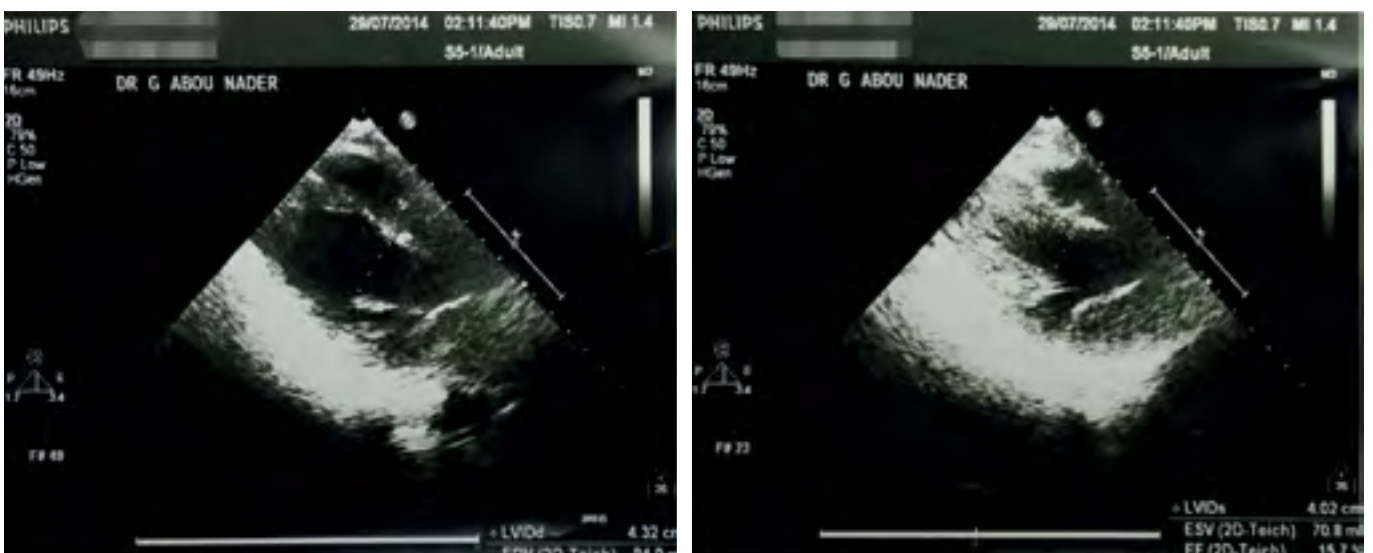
Left parasternal long axis view of the stress Echocardiogram, showing a diffuse hypokinesia of the myocardium with an Ejection Fraction (EF) of 15.7%, and Left Ventricular Internal Diameter end systole (LVIDs) of 4.02 cm ©EKaram
